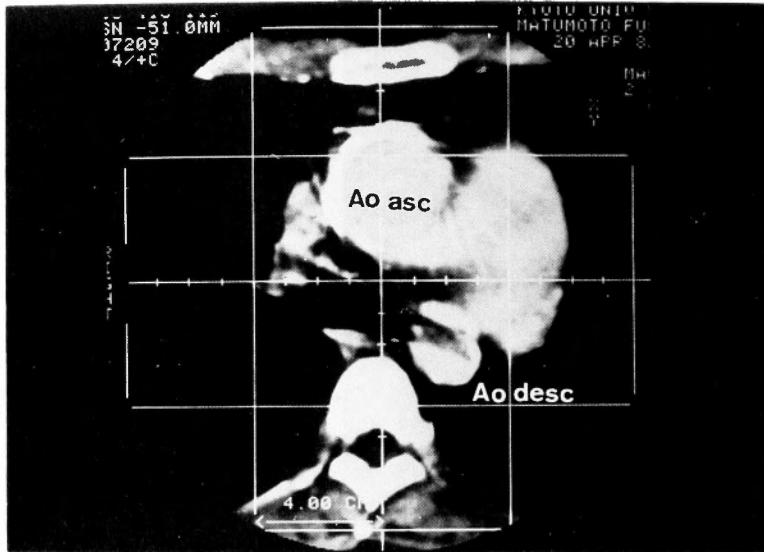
CT-scan of the chest reveals a severe calcium deposit in the walls of the ascending and descending aorta, but no mural thrombosis is found.
